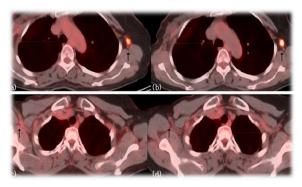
¹⁸F-FDG uptake left axilla on 50min (a), 90min (b) of malignant ALN and right axilla on 50min (c), 90min (d) of benign ALN in PET/CT
